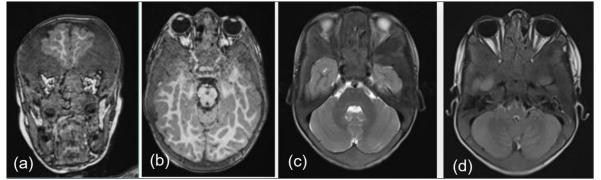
Coronal T1(a), axial T1 (b), axial T2 (c) and axial FLAIR (d) sequences showing heterogeneous thickening of craniofacial bones in the context of fibrous dysplasia
